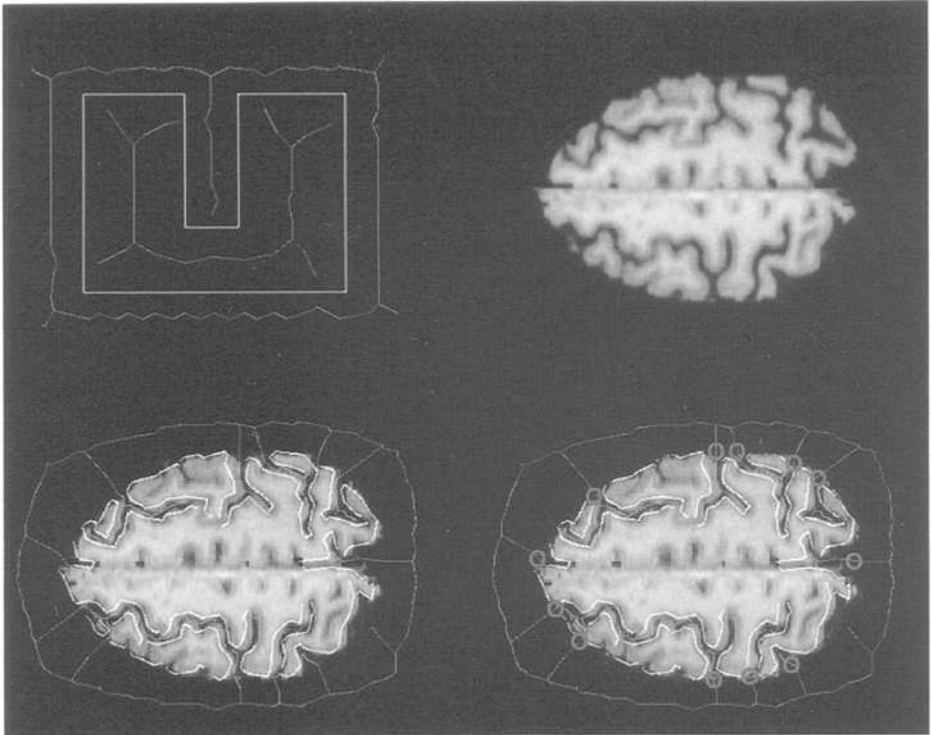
Top left (a): Test figure „U“ and its corresponding Voronoi segmentation. Top right (b): T1-weighted input MR slice 40mm above CA-CP. Bottom left (c): Polygonal approximation of the brain contour and its Voronoi segmentation. Bottom right (d): Crosspoints (shown as rings) with the convex hull are denoted as suspected sulcus entry points.
